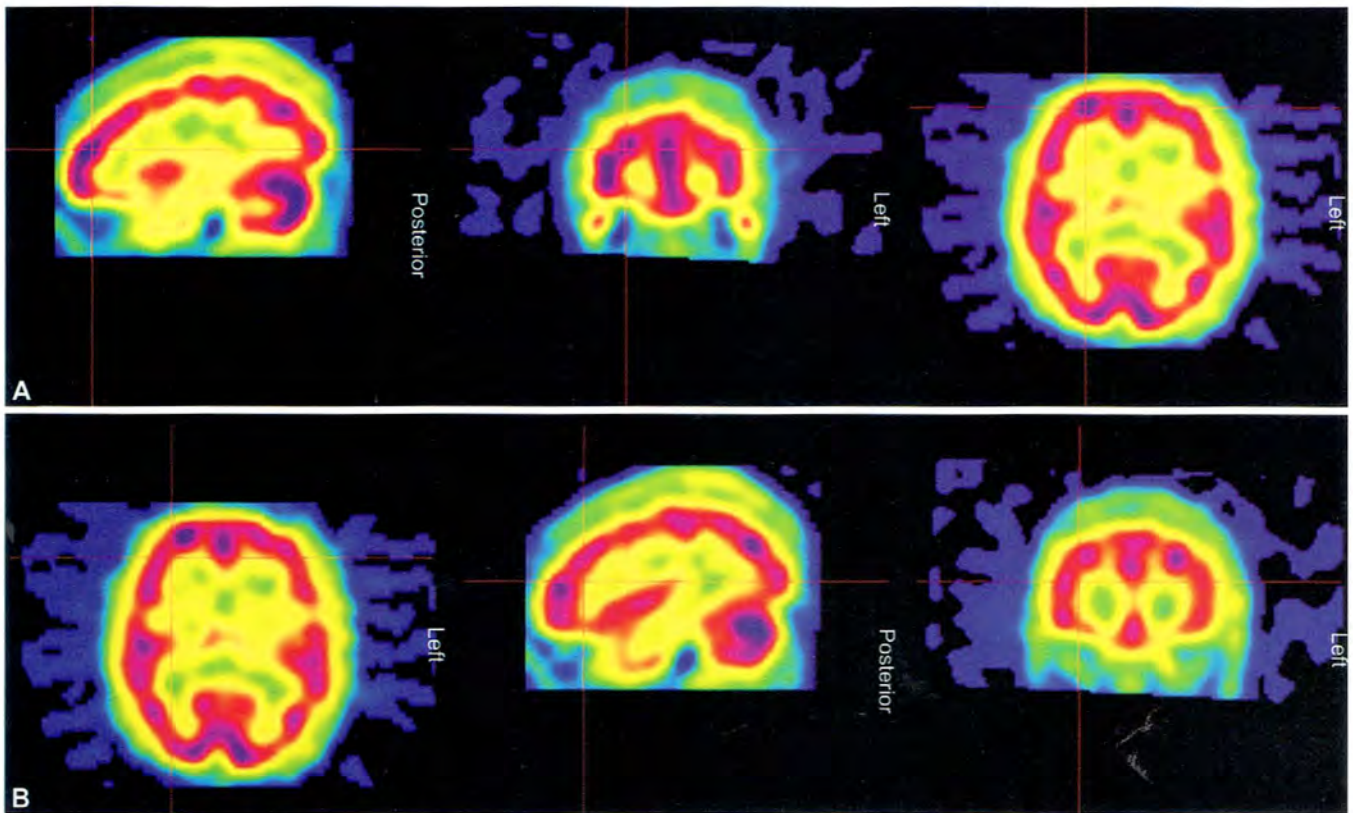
This interictal brain Tc-99m-hexamethylpropyleneamine oxime-single-photon emission computed tomography (HMPAO-SPECT) of the same patient demonstrates a small area of asymmetrically decreased perfusion in the left frontoparietal region. This defect could not be correlated with other examinations and may represent noise.
